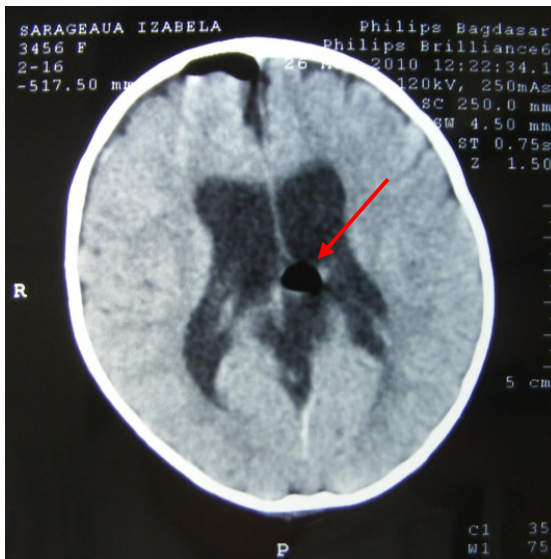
postoperative CT scan aspect of the same cyst as in figure 9, after endoscopic fenestration, and the patient
